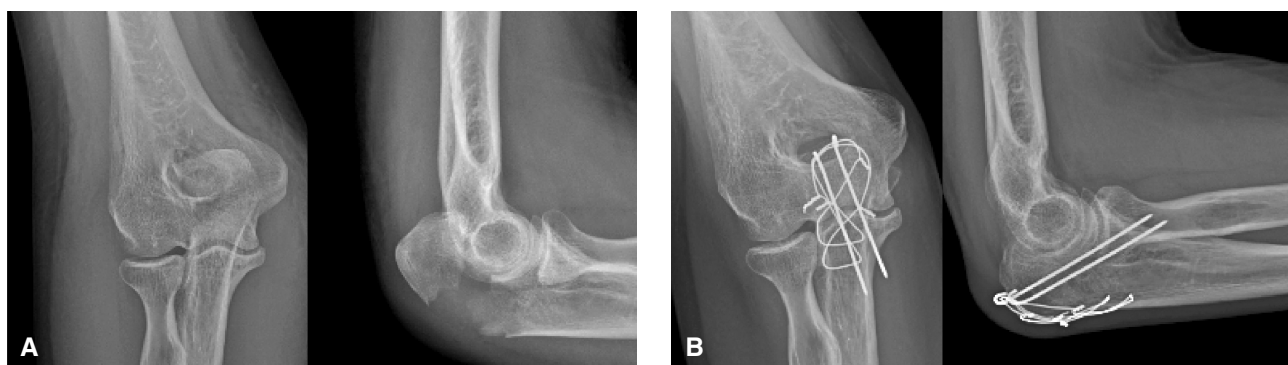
Displaced olecranon fracture in a 50-year-old female, sustained after tripping and falling on an outstretched right hand. A – Preoperative radiographs. B – Two months after Tension-band-wiring. The patient reported no pain or discomfort. Active ROM: extension–flexion arc 0–130°, supination 90°, pronation 90°.
